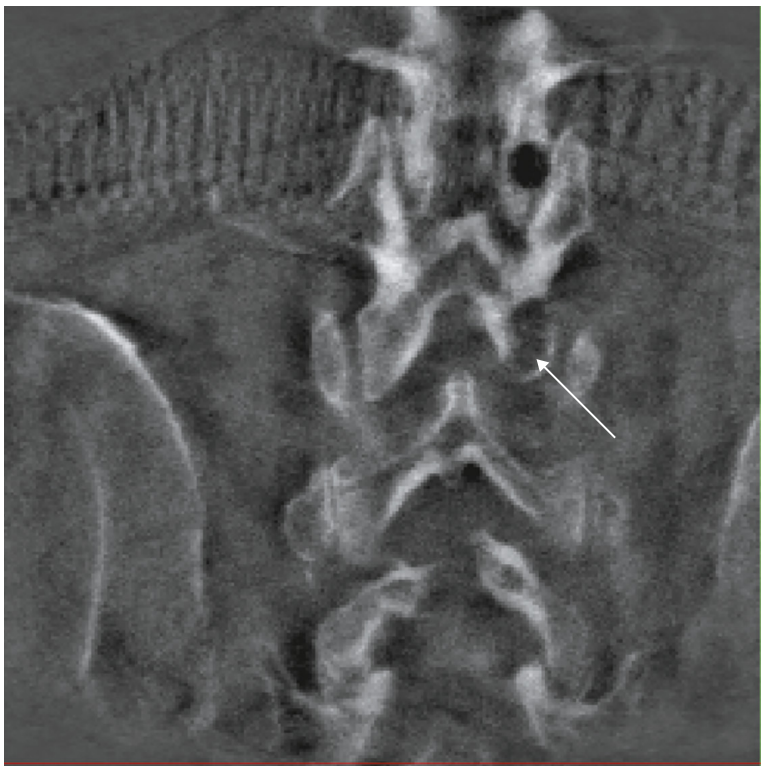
The partial bones of lamina (arrow) were precisely removed, as confirmed by the postoperative cone beam computed tomography scan and imaging reconstruction.
